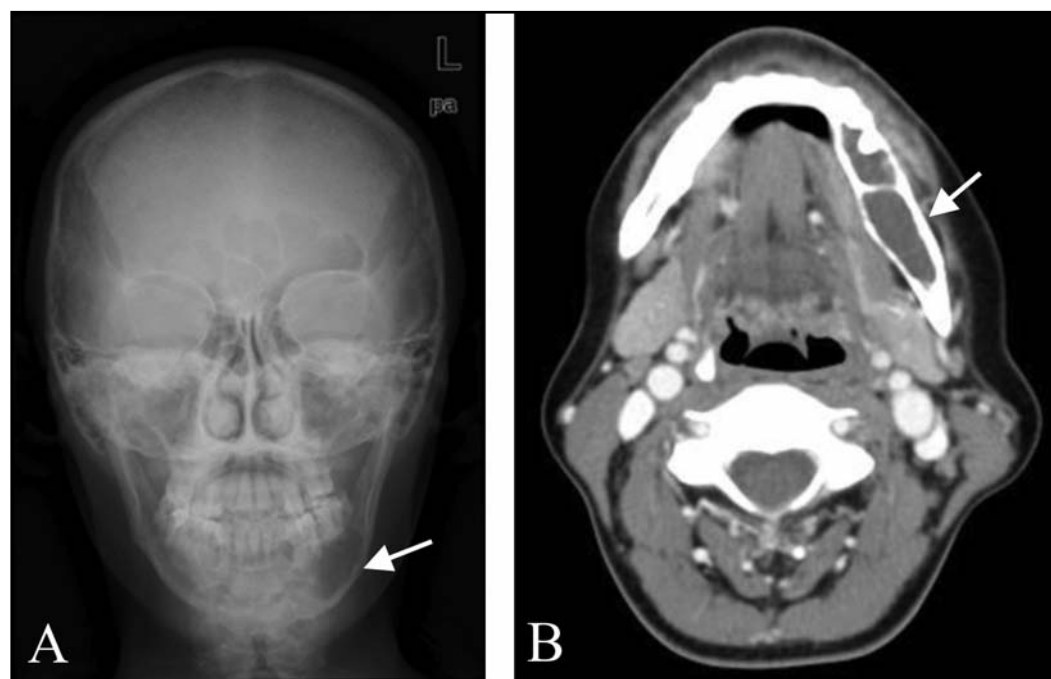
Brown tumor of the jaw. (A) Skull X-ray image of patient 3 showing a brown tumor in the left mandible (white arrow). (B) Spiral CT scan of patient 3 showing a lytic expansile lesion in the left mandibular body (white arrow).
